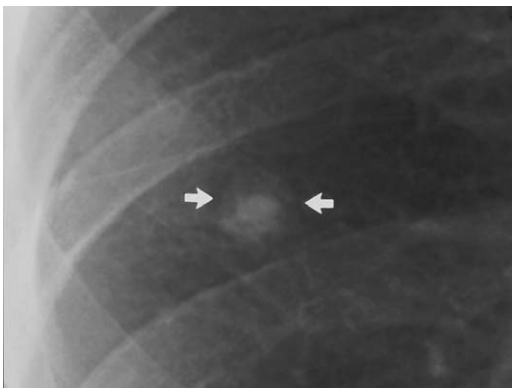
Targeted view of a chest radiograph showing a nodule (arrows) with central calcification compatible with a benign calcified granuloma.
